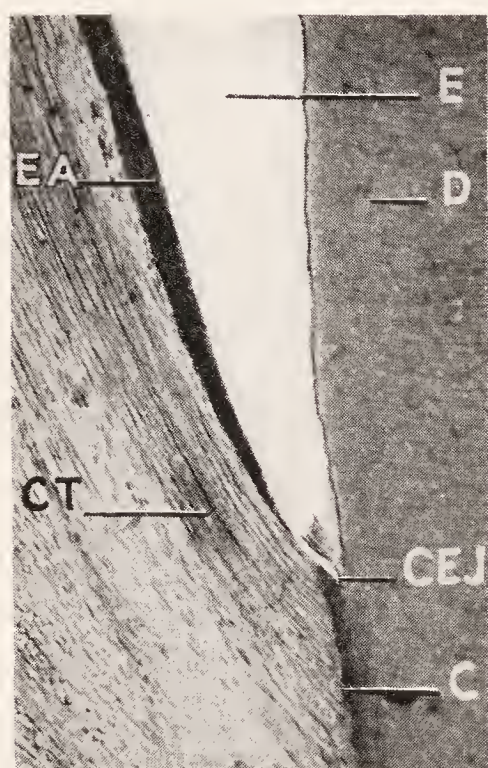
High magnification of the cemento-enamel junction in Fig. 223. D, dentin; E, enamel; CEJ, cemento-enamel junction; EA, epithelial attachment to the enamel; CT, connective tissue; C, cementum. Notice the complete absence of round-cell infiltration in the subepithelial connective tissue.
